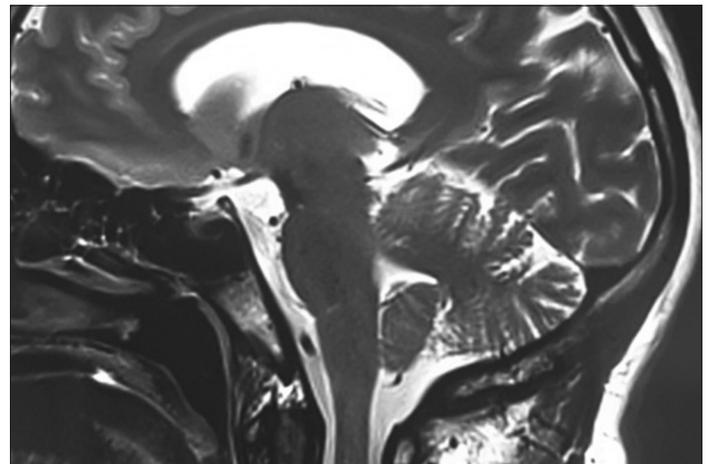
Preoperative cerebral MRI in sagittal section. There was no Chiari malformation.
